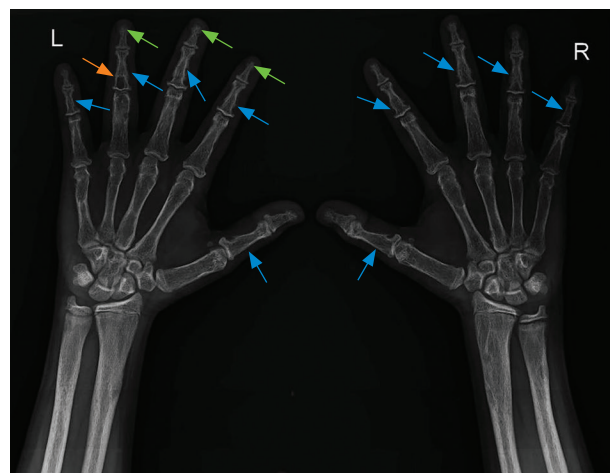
Radiograph of both hands showing generalized osteopenia with subperiosteal resorption (blue arrows) of the middle phalanx of the first, second, third, fourth and fifth fingers of both hands, brown tumor (orange arrow) in the middle phalanx of the fourth finger of the left hand and acro-osteolysis (green arrows) in the distal phalanx of the second, third and fourth finger of the left hand.
